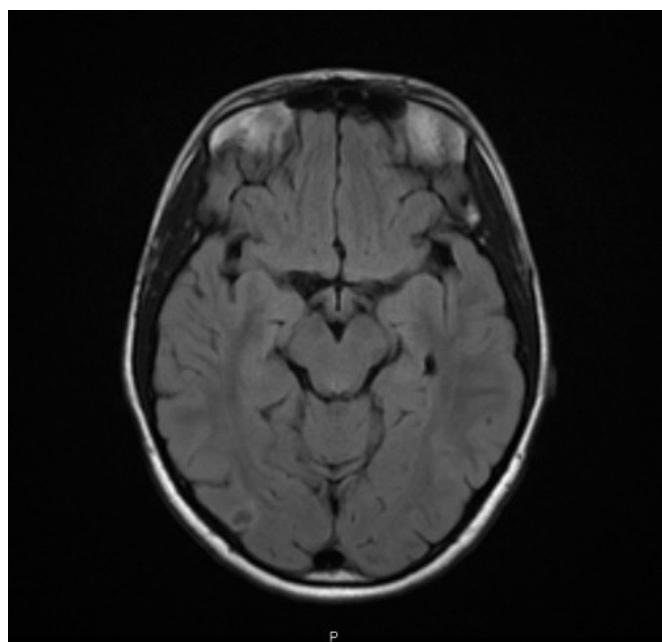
Cranioencephalic MRI (T2 flair axial) nearly 2 months after anti-toxoplasma therapy
